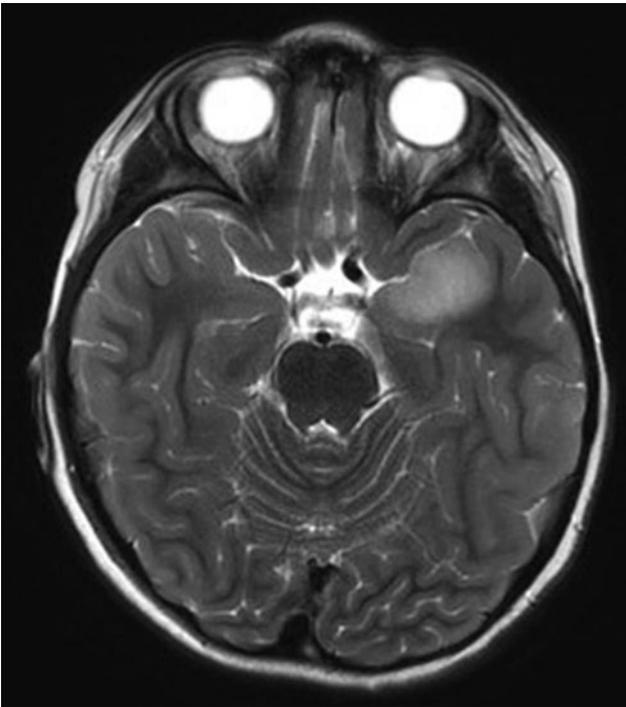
Axial T2-weighted magnetic resonance image. Although it was not enhancing and presented with some hippocampal signal change, the lesion was malignant, a primitive neuroectodermal tumor.
